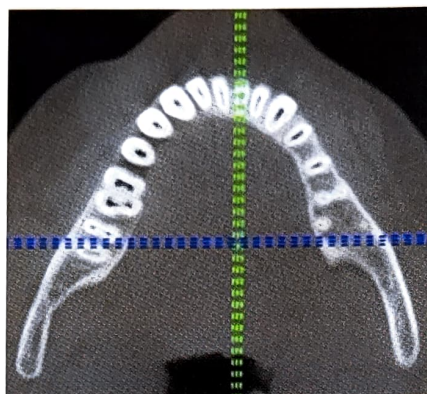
CBCT demonstrates axial 2-D slices of 46 showing extra root; Coronal third
